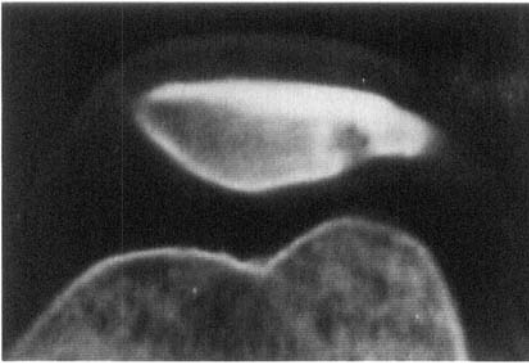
Case 5. 16-year-old man with CT scan showing osteochondritis dissecans of the lateral facet.
